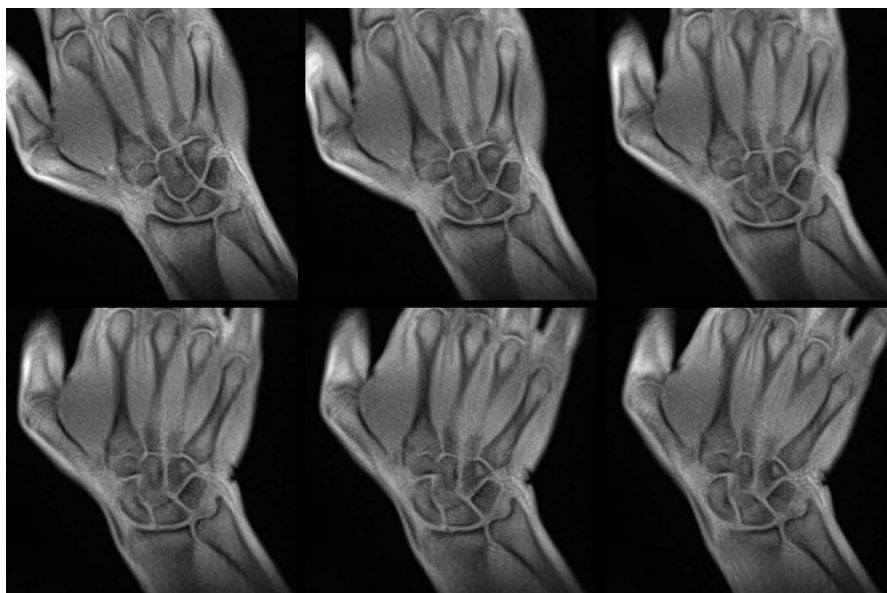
Wrist movement. Selected frames (coronal views from top left to bottom right) of a real-time MRI movie of the hand during left-right movement (50 milliseconds acquisition time, 0.75 mm resolution, 4 mm slice thickness). The frames are 40 images apart (2.0 seconds).
